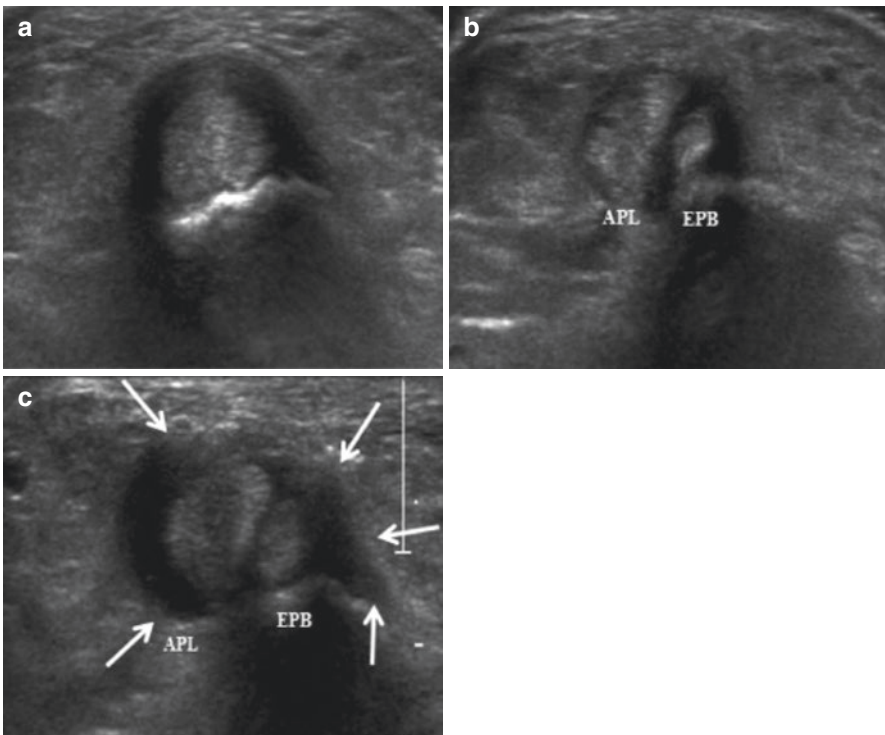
(a) Thickening of the synovium within the first extensor compartment. Ultrasonogram. Hypoechoic area represents thickened synovium. (b) “Complete” compartmentalization of the abductor pollicis longus and extensor pollicis brevis in distinct compartments ultrasonogram. *APL* abductor pollicis longus, *EPB* extensor pollicis brevis. (c) Hypoechoic appearance of a septum between the adductor pollicis longus and extensor pollicis brevis tendons ultrasonogram. Arrows indicate hypoechoic appearance of the septum between the *APL* and *EPB*. *APL* abductor pollicis longus, *EPB* extensor pollicis brevis
